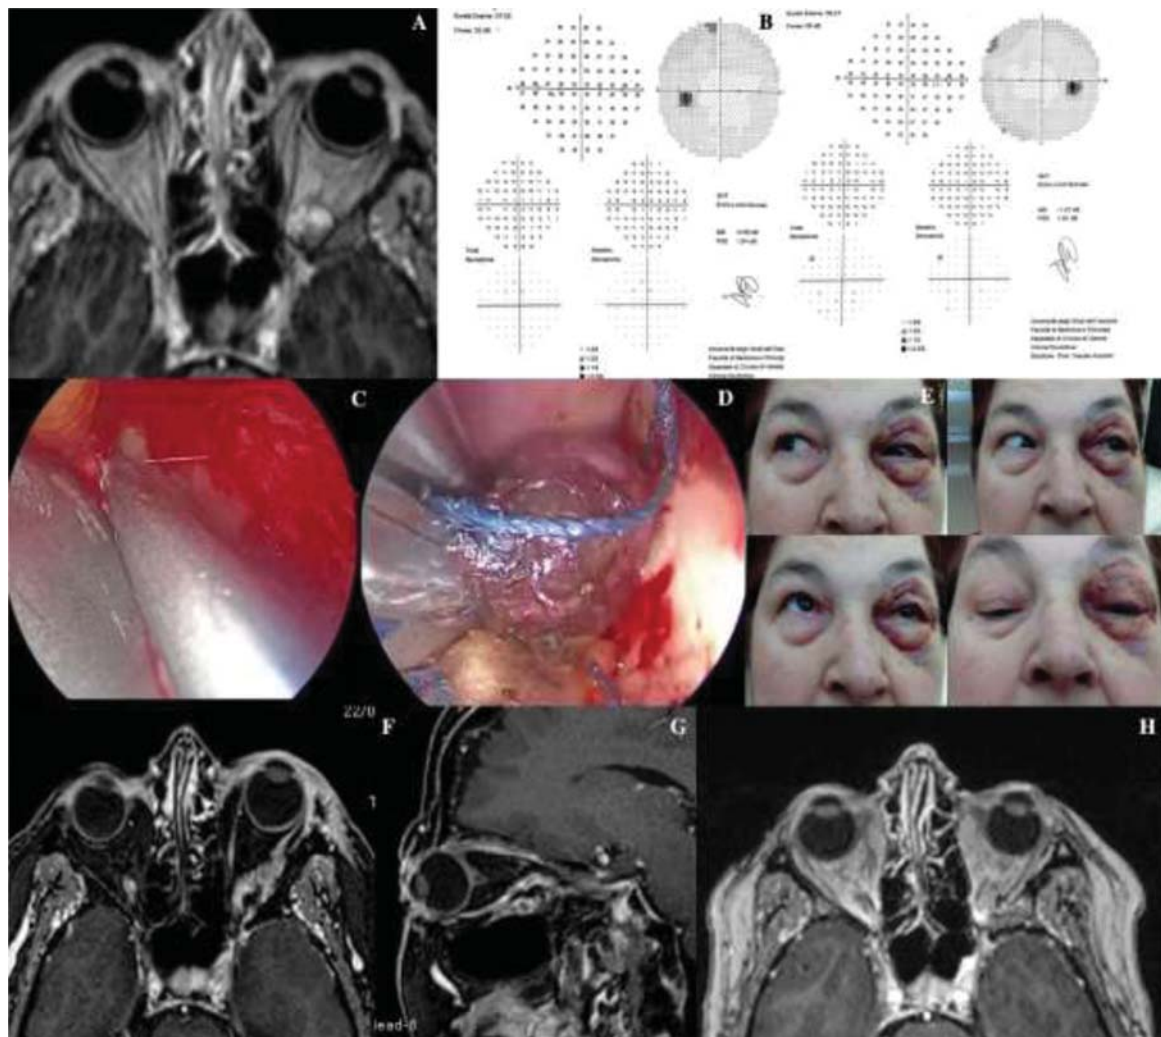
Superior eyelid approach to intraconal cavernous hemangioma. (A, B) Axial T1 post-contrast MRI demonstrating a cavernous hemangioma within the left orbital apex with associated visual field impairment. (C, D) Endoscopic trans-superior eyelid approach for resection of the lesion with post-operative external swelling and mild diplopia. (E-H) Postoperative MRI images demonstrating complete removal of the lesion.
